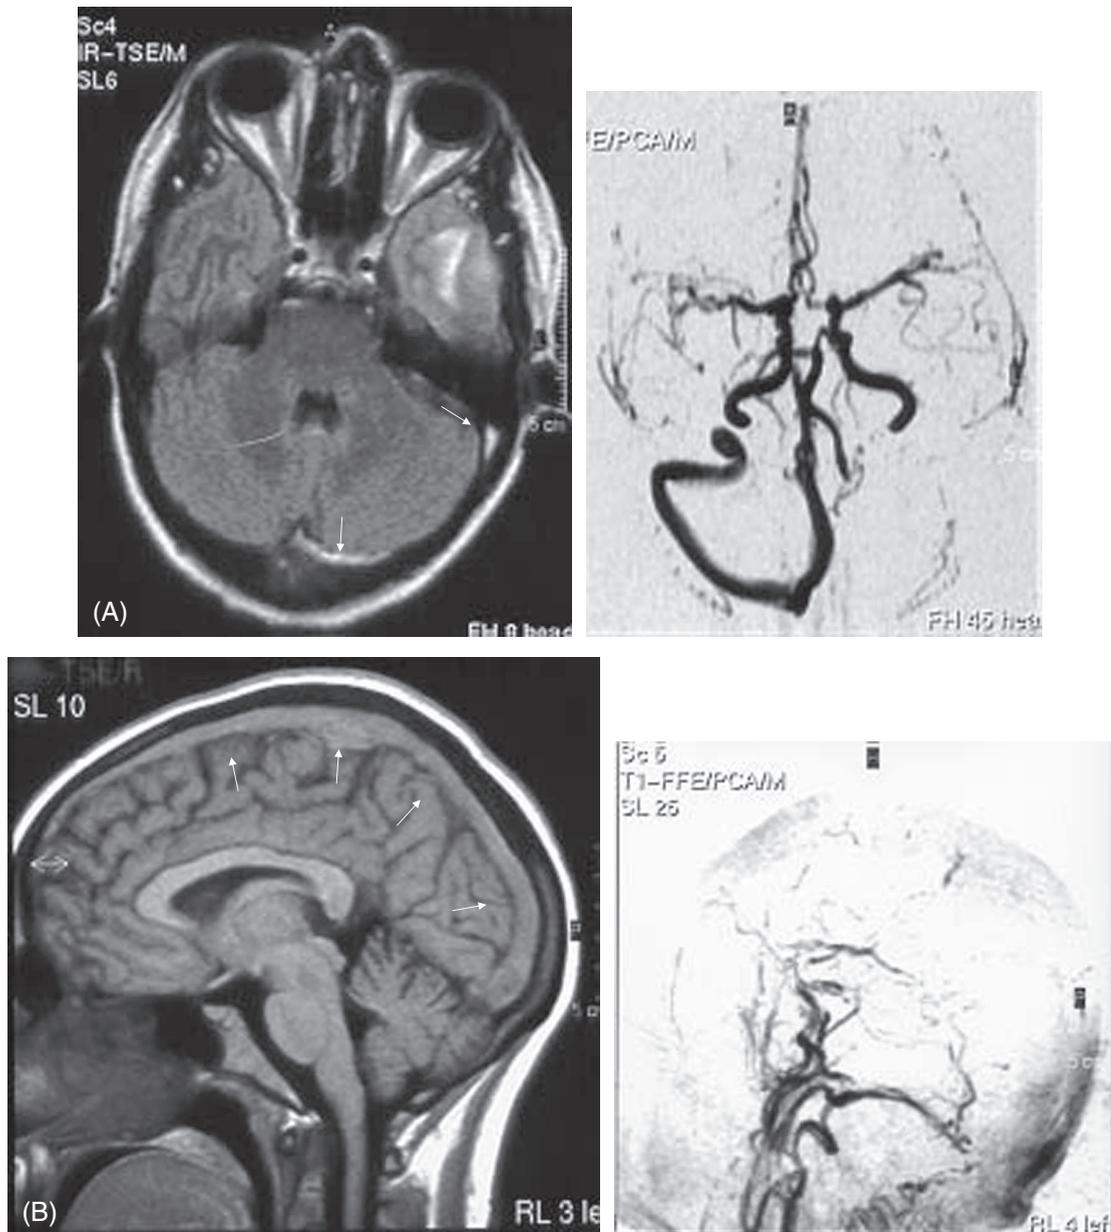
Magnetic resonance imaging of sinus thrombosis. (A) T2-weighted MRI. Increased signal in left lateral sinus (arrows), with a left temporal lesion. Magnetic resonance venogram confirms the absence of signal in the left lateral sinus and normal flow in the remaining sinus. (B) T1-weighted MRI provides a sagittal view of an isointense signal in the thrombosed superior sagittal sinus (arrows). Magnetic resonance venogram confirms the absence of signal in the superior sagittal sinus and the deep cerebral venous system.
